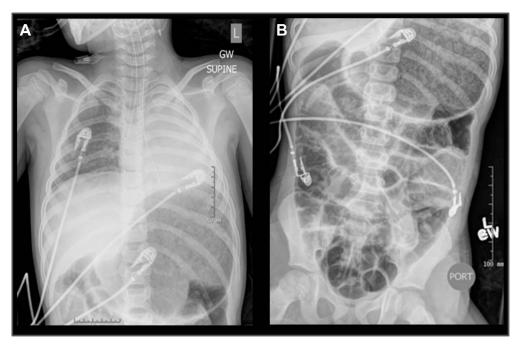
Chest (A) and abdominal (B) radiographs demonstrate prominent gastric and bowel distention.
